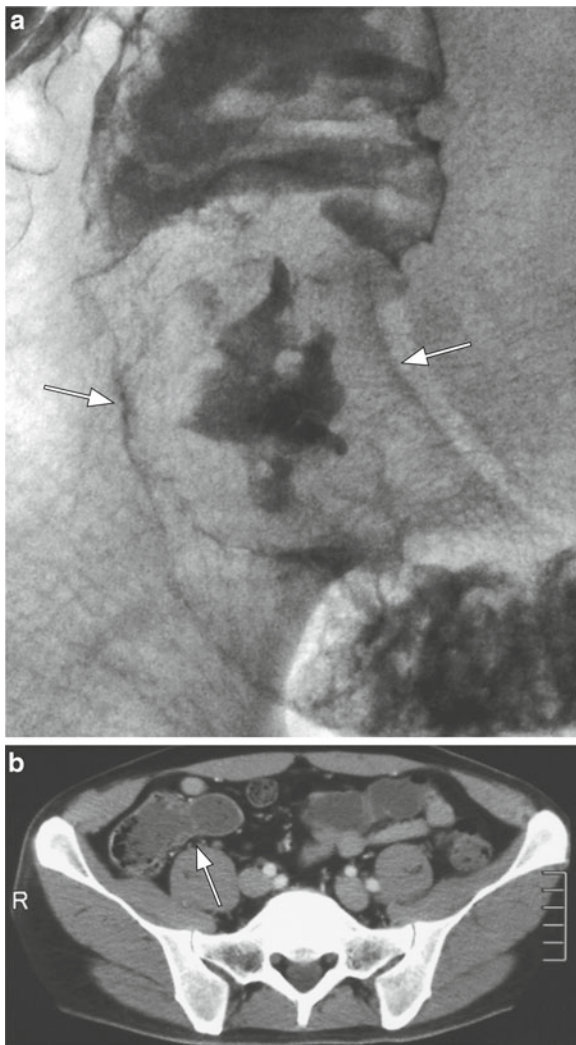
Radiography showed formation of an irregularly shaped ulcer with a deep central area (a). Contrast-enhanced CT showed thickening of the ileal wall with mild dilation of the intestine on the proximal side (b)
